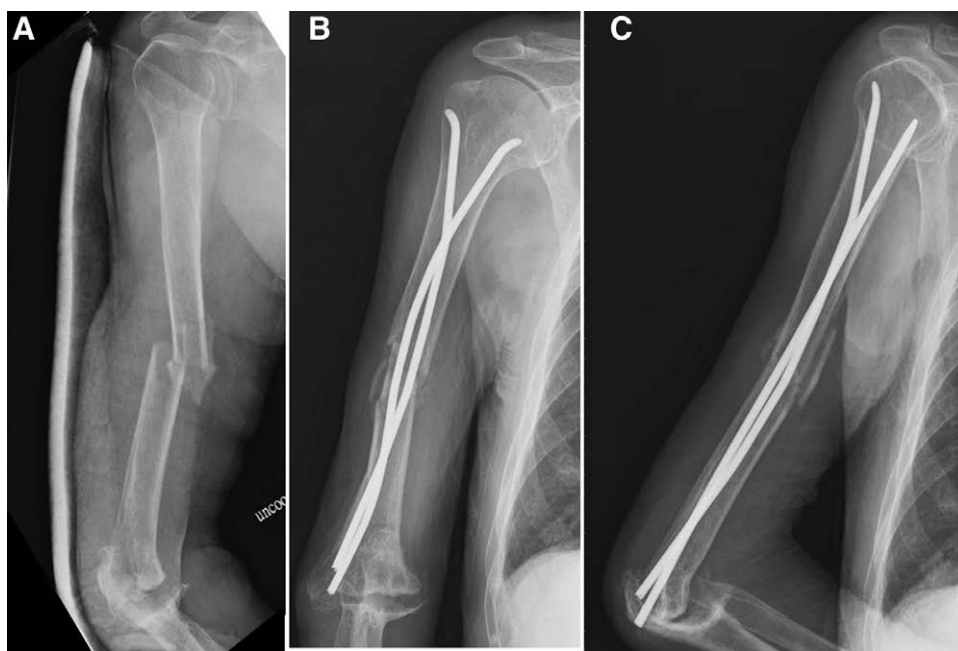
An 85-y-old woman with stage III-IV congestive heart failure who could not tolerate severe pain and was at high risk for general anesthesia. A, Preoperative X-ray (B), post-operative X-ray (C) show two 4.0-mm titanium elastic nails (TENs) that were inserted in a retrograde manner and were divergent over the proximal humerus.
